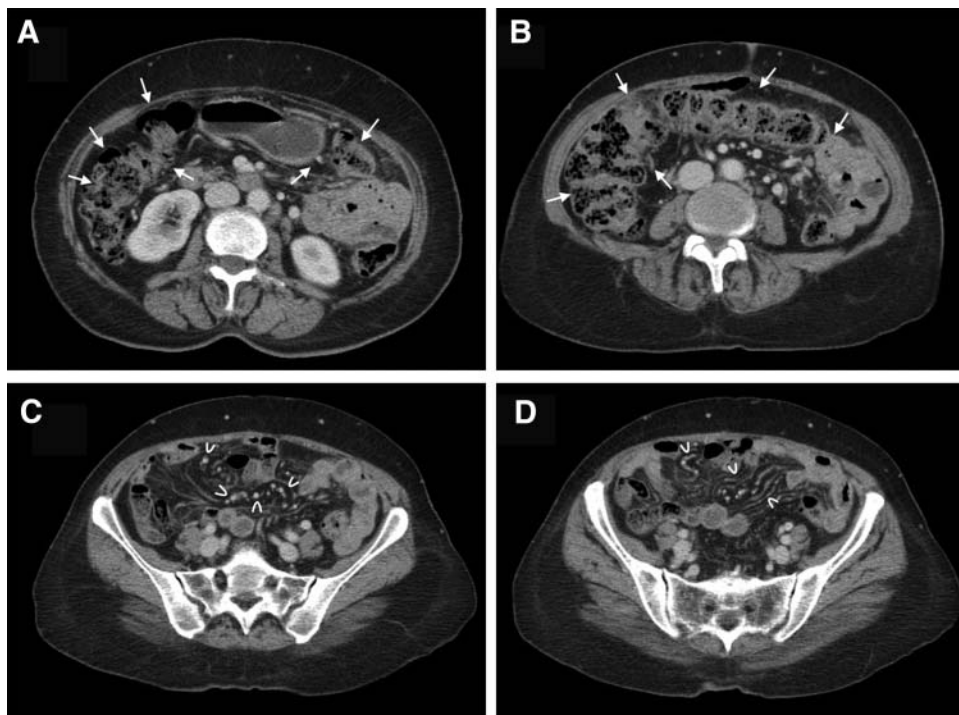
Contrast-enhanced abdominal and pelvis computed tomography scans in the axial plane show intestinal thickening and significant stool impaction (A, B, arrows) secondary to mechanical obstruction from fibrosis and thickening of sarcoidosis that involved the greater omentum (C, D, curved arrowheads) and other abdominal organs.
